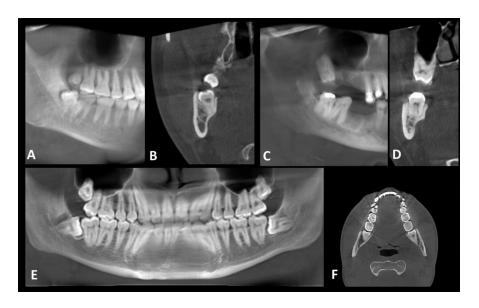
CBCT images of molar impaction: (A) Case 4, panoramic reconstruction showing distoangularly impacted mandibular right third molar; (B) Cross section of the same case; (C) Case 5, panoramic reconstruction showing vertical impaction of maxillary right third molar; (D) Cross section of the same case;
